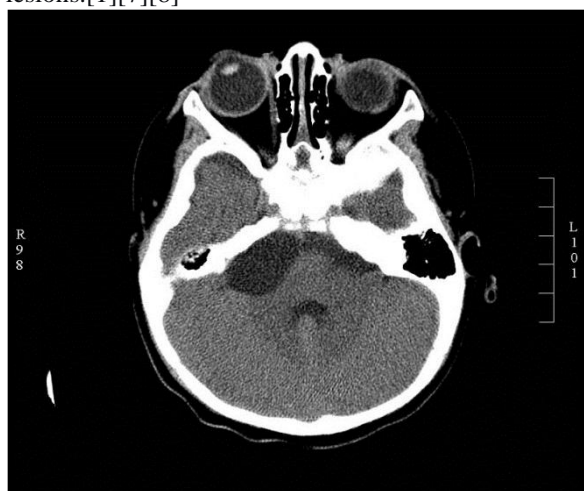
CT Scan of Arachnoid Cyst.
